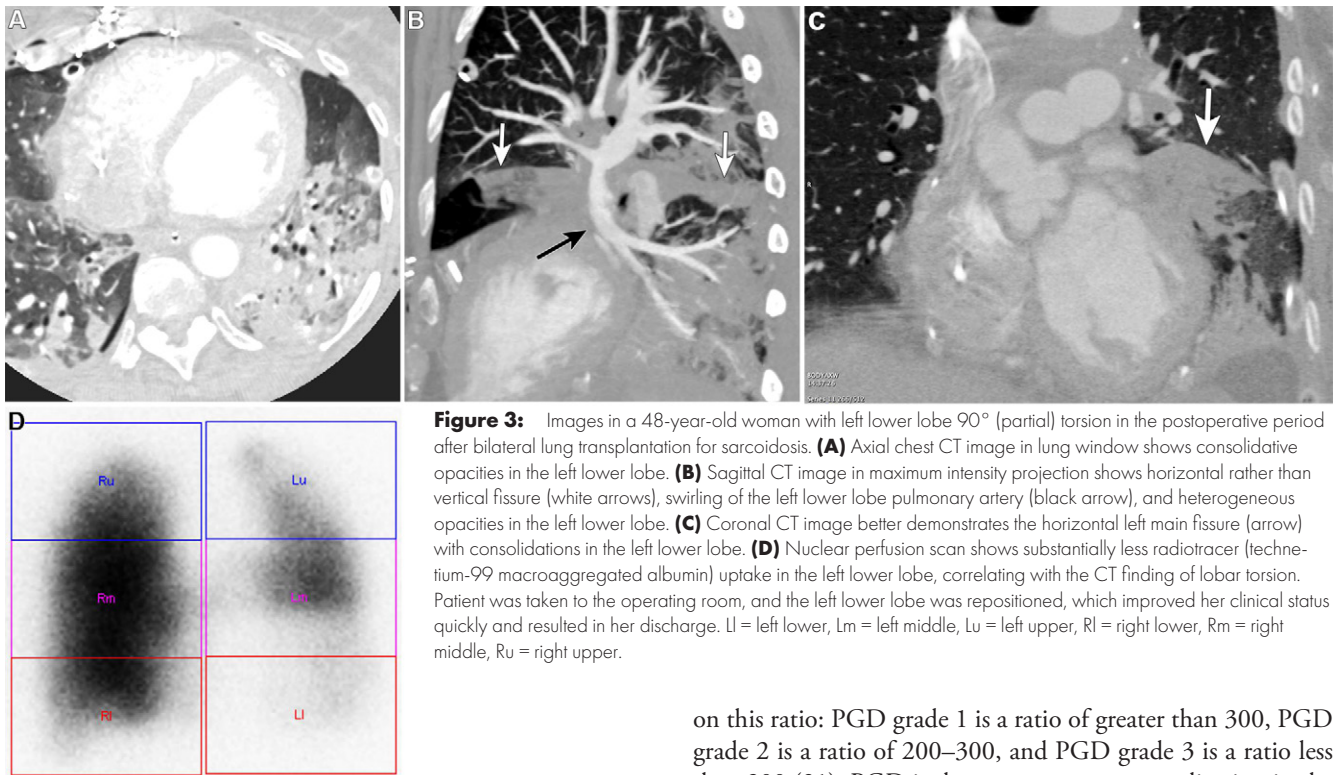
Images in a 48-year-old woman with left lower lobe 90° (partial) torsion in the postoperative period after bilateral lung transplantation for sarcoidosis. (A) Axial chest CT image in lung window shows consolidative opacities in the left lower lobe. (B) Sagittal CT image in maximum intensity projection shows horizontal rather than vertical fissure (white arrows), swirling of the left lower lobe pulmonary artery (black arrow), and heterogeneous opacities in the left lower lobe. (C) Coronal CT image better demonstrates the horizontal left main fissure (arrow) with consolidations in the left lower lobe. (D) Nuclear perfusion scan shows substantially less radiotracer (technetium-99 macroaggregated albumin) uptake in the left lower lobe, correlating with the CT finding of lobar torsion. Patient was taken to the operating room, and the left lower lobe was repositioned, which improved her clinical status quickly and resulted in her discharge. Ll = left lower, Lm = left middle, Lu = left upper, Rl = right lower, Rm = right middle, Ru = right upper.
